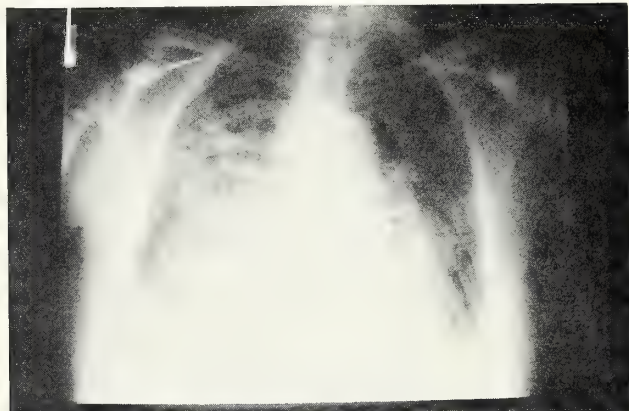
Chest x-ray (second admission) eight hours before death.
